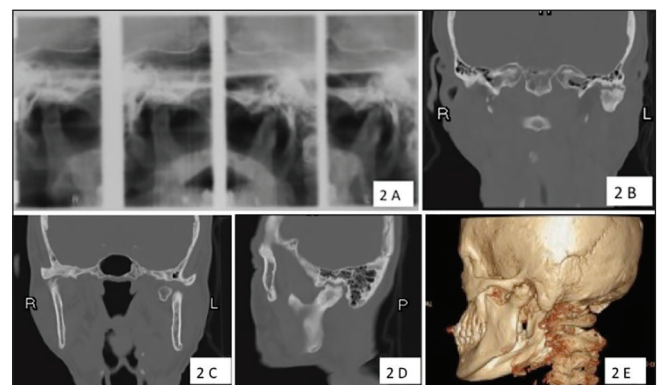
Initial radiography and computed tomography. (a) Plain radiography of the temporomandibular joint revealed the limitation of the joints bilaterally, and the shapes of the condylar heads differed. The left condylar head of the mandible exhibited erosion. (b-d) Computed tomography in coronal (b and c) and sagittal (d) views show flattening and deformity of the left condyle. (c) The previous sagittal fracture of the left condylar head is evident. (d) Bony fusion is present at the outer edge of the articular surface, but there is no fusion in the remainder of the left condylar joint. (e) The erosive condylar head was adhered to the glenoid fossa
